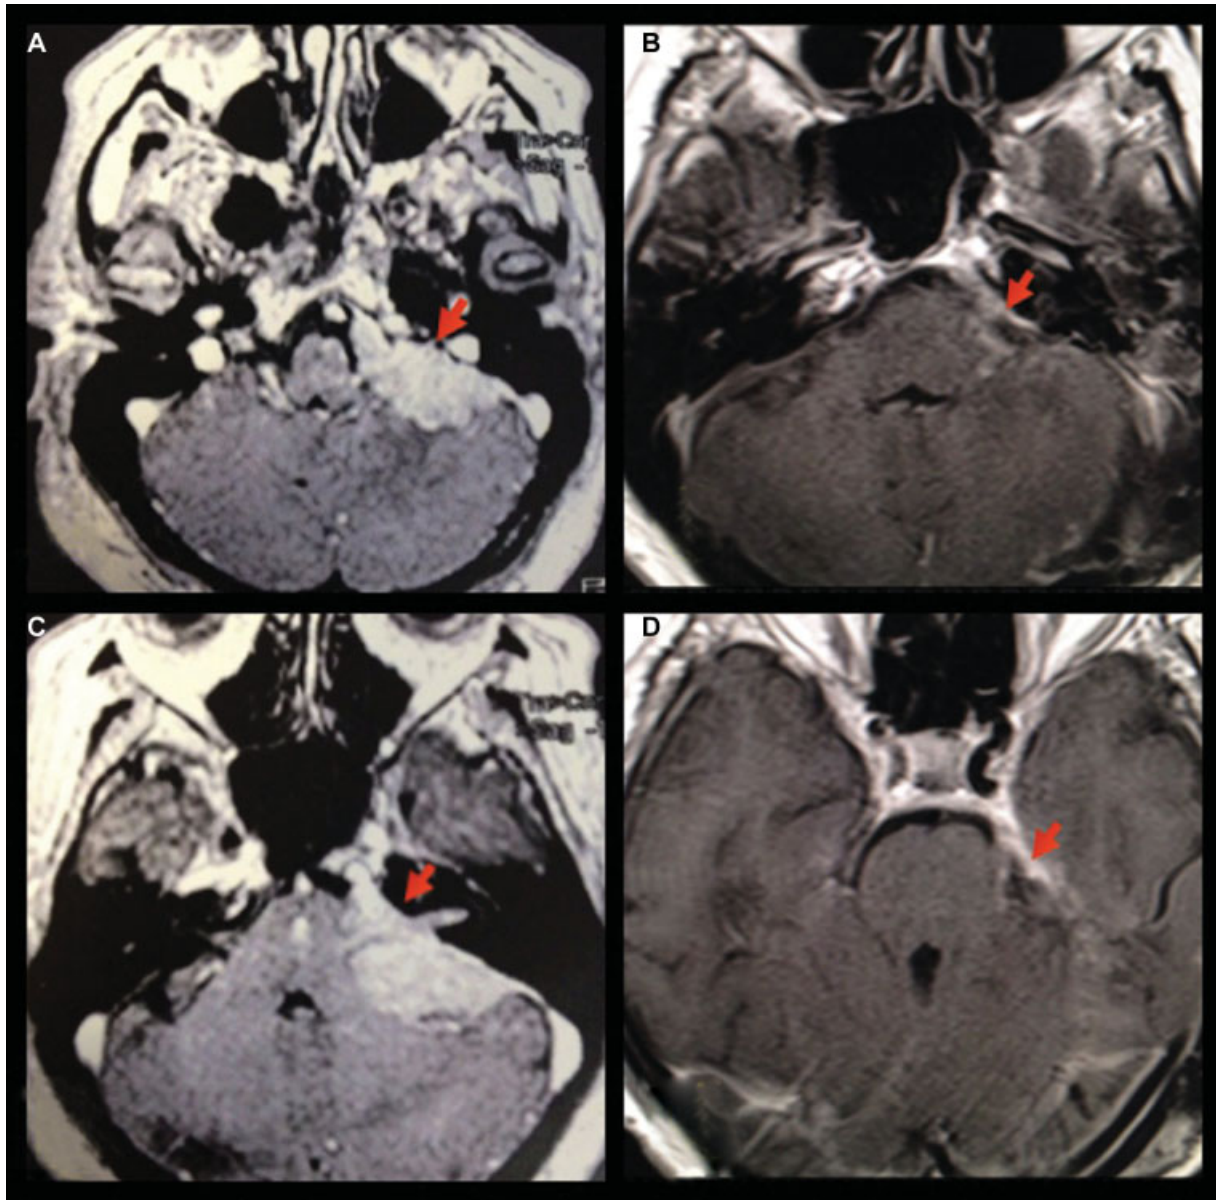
(A and B) Preoperative MRI demonstrating the tumor extension to the pre- and postmeatal region of the left cerebellopontine angle; (C and D) postoperative MRI with complete tumor removal. MRI, magnetic resonance imaging.
